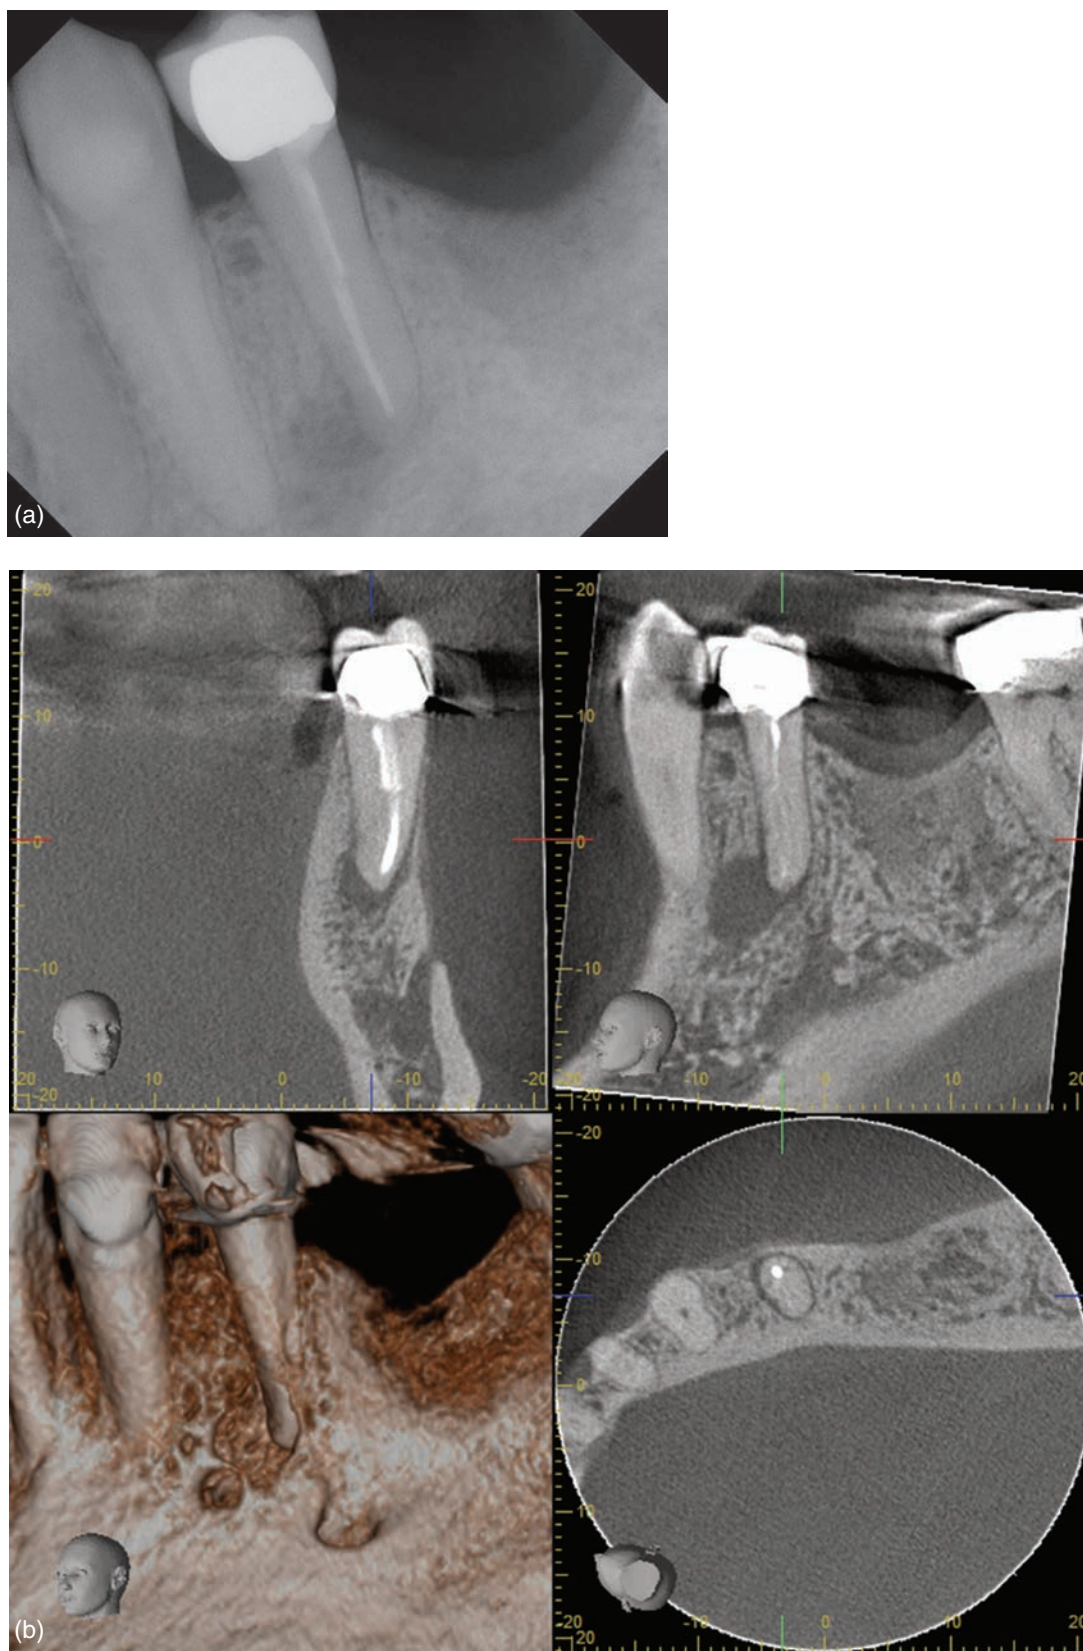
Previously treated mandibular premolar. (a) Periapical radiograph showing apical pathology. The tooth was restored with a PFM crown. (b) CBCT images show lesion associated with the tooth and close proximity to the mental foramen. Due to the location of the mental foramen non-surgical treatment was chosen.
